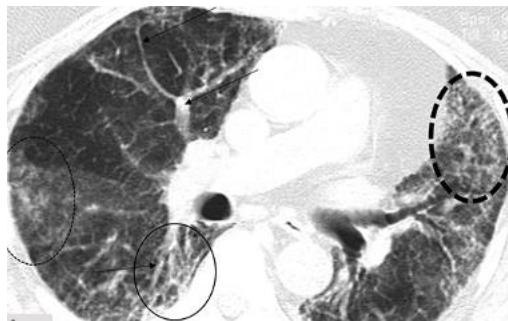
An axial HRCT image of an 85-year-old man with post-COVID-19 pulmonary fibrosis shows extensive reticulations, prominent pulmonary vessels, volume loss, patchy consolidation, and a fine honeycomb appearance, particularly in the periphery.
